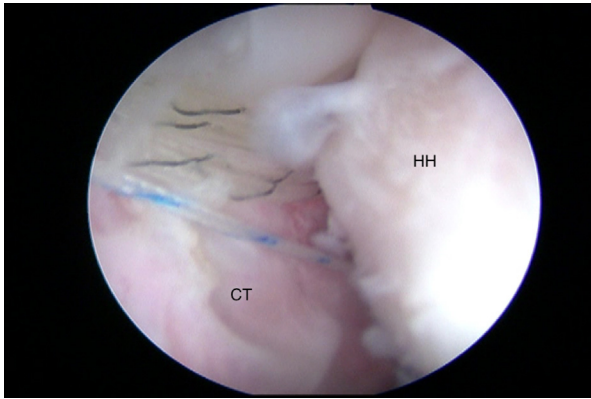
The humeral Q-FIX anchors are double-loaded with two sets of different-colored sutures. All 4 suture limbs from the inferior humeral anchor are brought through the antero-inferior portal using the suture retriever. Three suture limbs are then passed together through the lateral-inferior aspect of the graft, from inside-to-outside direction. The same step is repeated with the superior humeral Q-FIX anchor and then passed through the lateral-superior aspect of the graft in an inside-out fashion. A view from the anterosuperior portal on the right shoulder. CT, capsular tissue; HH, humeral head.
